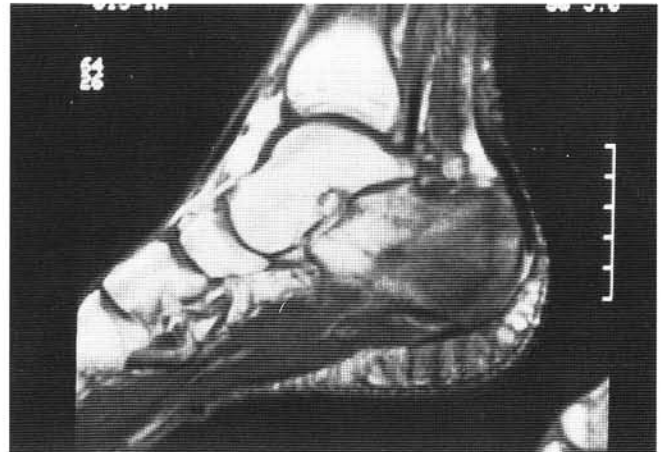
T1-weighted MR image of same patient. Note decreased signal intensity and presence of calcaneal fracture. Infection could not be ruled out since the patient had been admitted for same leg cellulitis.
